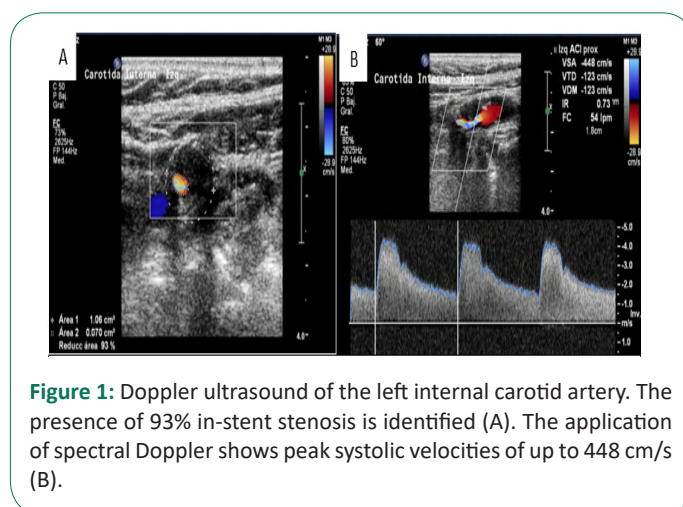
Doppler ultrasound of the left internal carotid artery. The presence of 93% in-stent stenosis is identified (A). The application of spectral Doppler shows peak systolic velocities of up to 448 cm/s (B).
